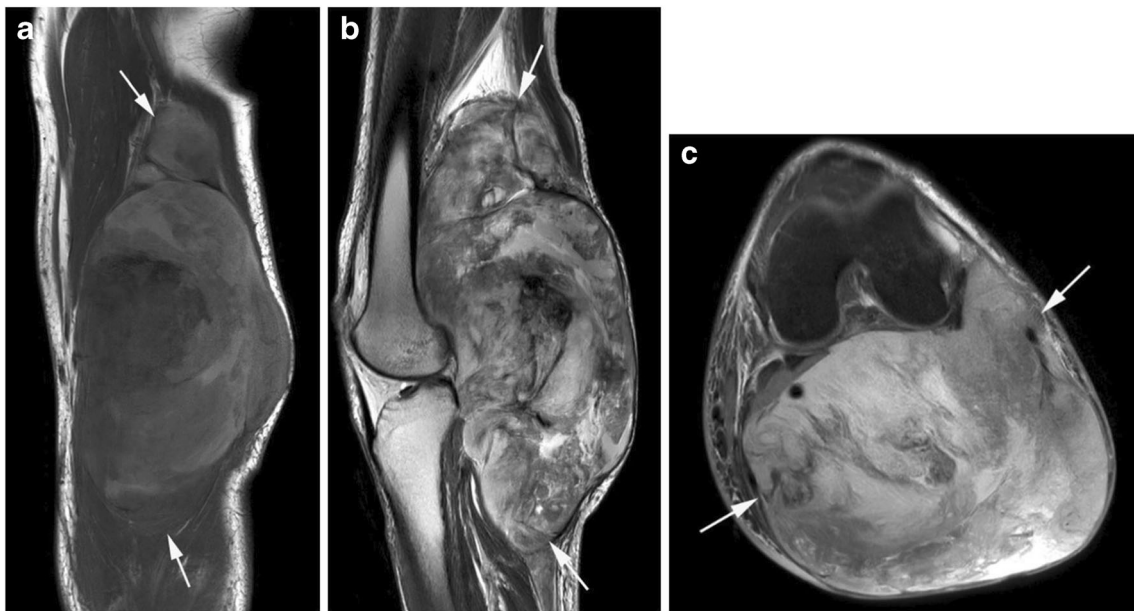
A 55-year-old male presenting with a large mass in the right popliteal fossa. a Coronal T1W TSE, b sagittal T2W FSE, and c axial SPAIR MR images show a well-defined, lobular mass (arrows) which
